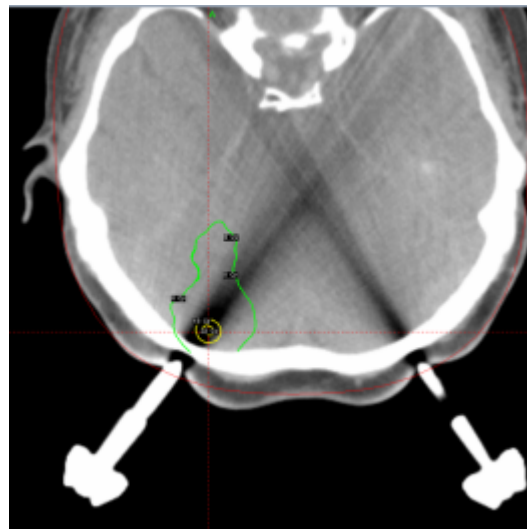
CT artefact from titanium fixation pin introducing significant error to the convolution calculation. Small brain metastasis (TV: 0.057 ml) located precisely under the Leksell G frame pin causes significant CT scan distortion and shorter beam-on-time if the convolution algorithm is used.
